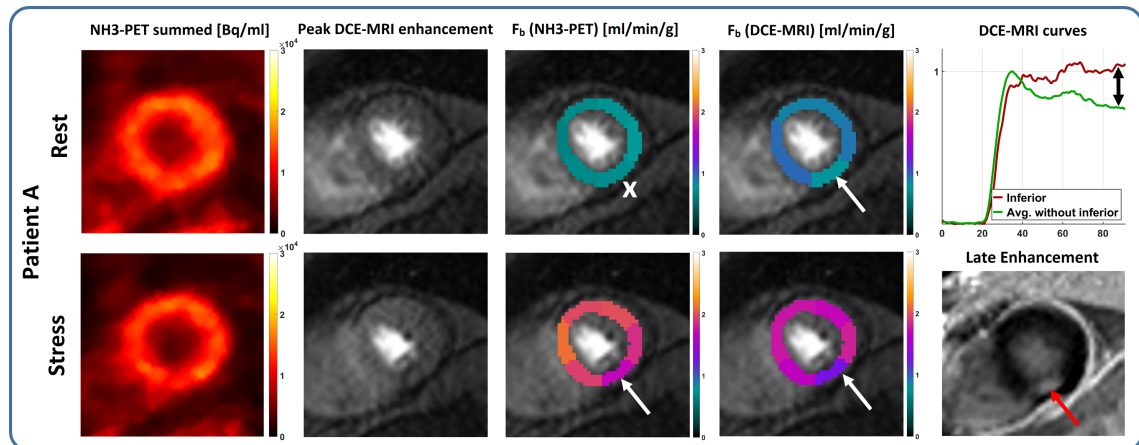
Clinical example case for integration of PET, DCE and LGE data for a patient 6 months after myocardial infarction following an occlusion of the proximal RCA. The highlighted inferior perfusion defect appeared as stress-inducible in PET, which would have led to a misclassification of the deficit as being indicative of a high-grade RCA stenosis. While invasive coronary angiography did not reveal a potential culprit stenosis, both the resting state DCE-MRI exam as well as LGE revealed an increased extracellular volume consistent with fibrotic tissue alterations.
